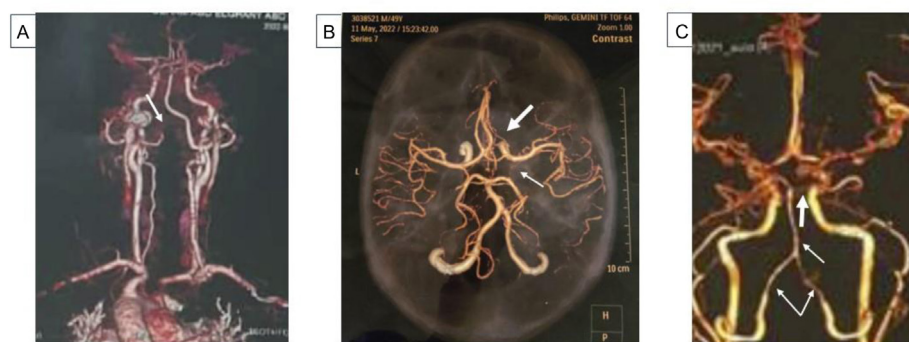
(A) Female patient, 42 years old, suffering from rapidly progressive extra-pyramidal manifestations over 2 months. MRA; attenuated left vertebral artery (arrow). (B) Male patient, 43 years old. Neurologic manifestations: numbness, affected cognitive functions, headache, lightheadedness, recent onset extrapyramidal manifestation, loss of morning erection. CTA; occluded left posterior communicating artery (supplying red nucleus in brain), thin arrow. Attenuated right anterior cerebral artery (thick arrow). (C) Male patient, 22 years old. Neurologic manifestations: severe headache of 6 years duration, TIAs, loss of consciousness and progressive respiratory distress over 2 months with fatal outcome. CTA; attenuated both vertebral arteries, basilar artery (thin arrow), and right posterior cerebral artery (thick arrow) with open collaterals. CTA, computed tomography angiography; MRA, magnetic resonance angiography; TIA, transient ischemic attack.
